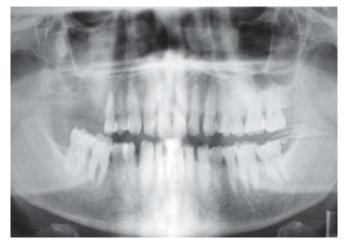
Orthopantomograph showing apparent relationship to sinus
